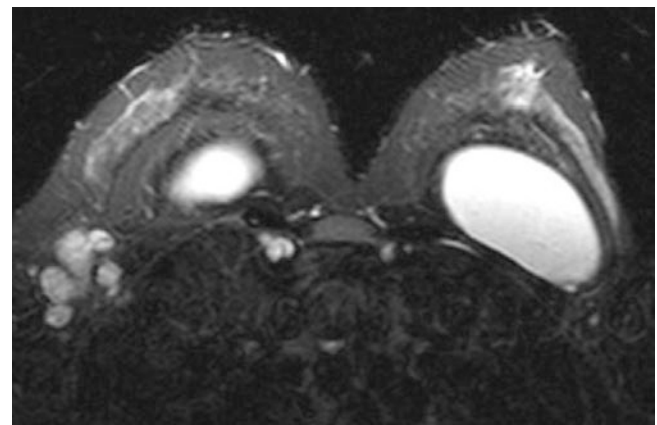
Breast MRI, white silicone sequence, showing extracapsular silicone in the axilla and internal mammary lymph nodes. This image appeared in the European Aesthetic Plastic Surgery Journal (number 12). Reproduced with permission from the Asociación Española de Cirugía Estética Plástica.
